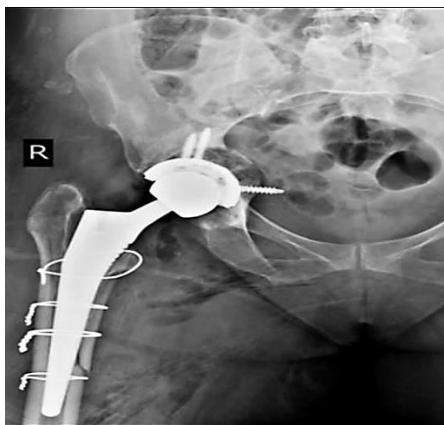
Anteroposterior (AP) X-ray radiography of the pelvis after six-month follow-up
